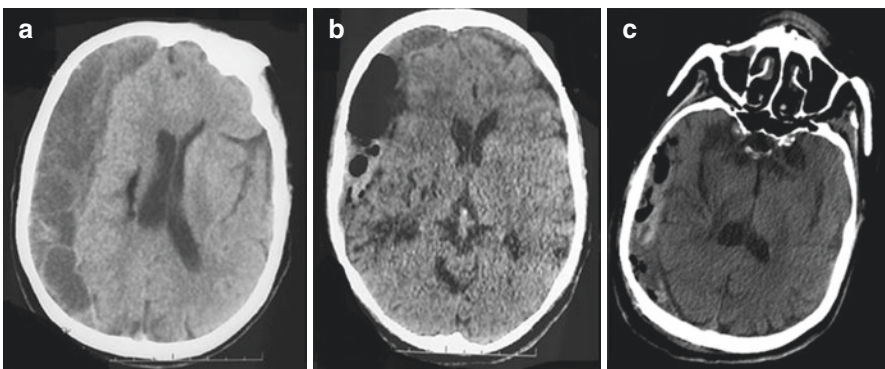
(a) Initial brain CT scan demonstrating right compressive frontoparietal CSDH. (b, c) Immediate postoperative CT scan revealing postoperative pneumocephalus inside the hematoma cavity
